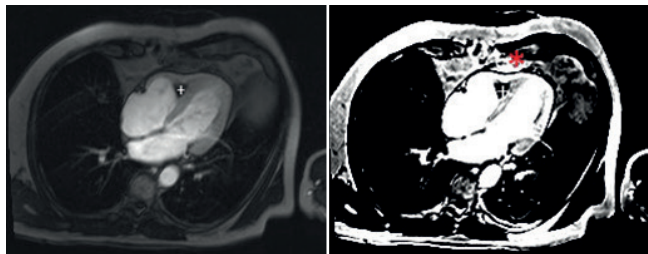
Snapshots from cardiac MRI. *RV apex endocardial enhancement; +Low signal keeping with thrombus
